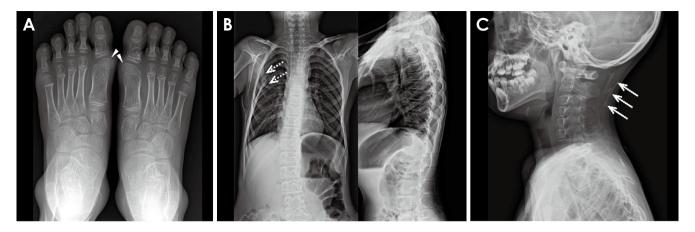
A. A bilateral weight-bearing dorsoplantar radiograph shows bilateral hallux valgus characterized by medially deviated and deformed first metatarsal heads, as well as deformed first proximal phalangeal bases (arrowhead). B. Full-spine anteroposterior and lateral radiographs show large bars of heterotopic ossification connecting the right scapula to the chest wall (open arrow). C. A lateral skull radiograph reveals a focal linear area of heterotopic ossification in the posterior neck area (arrow).
